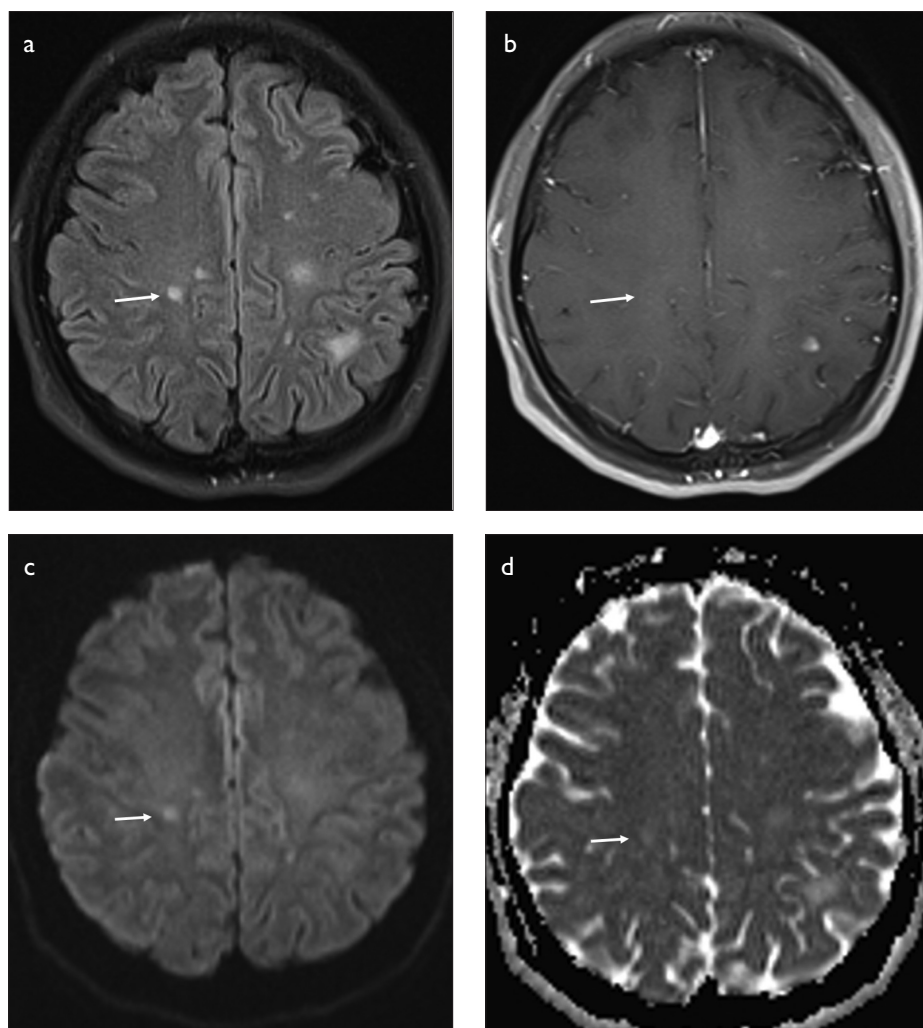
a-d. a) Axial plane FLAIR image of a patient with non-active MS lesion at the right centrum semiovale (arrow). b) Axial plane contrast enhanced image of a patient with non-active MS lesion at the right centrum semiovale. Lesion is not enhancing (arrow). c) Axial plane diffusion weighted image of a patient with non-active MS lesion at the right centrum semiovale. Lesion is hyperintense on diffusion weighted image (arrow). d) Axial plane ADC map of a patient with non-active MS lesion at the right centrum semiovale. There is no diffusion restriction (arrow).
